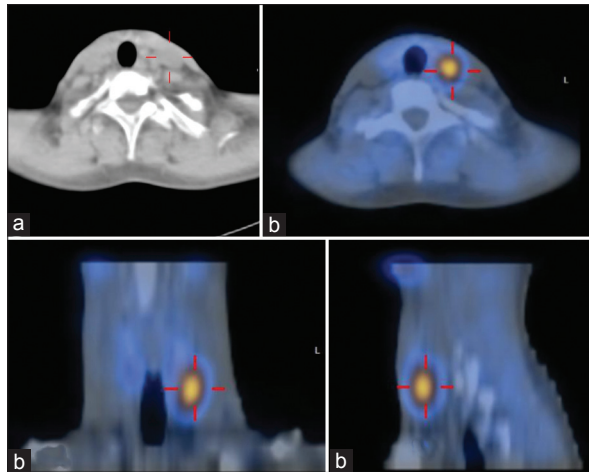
(a-b) Single-photon emission computed tomography images confirming the exact anatomical location of the parathyroid adenoma
